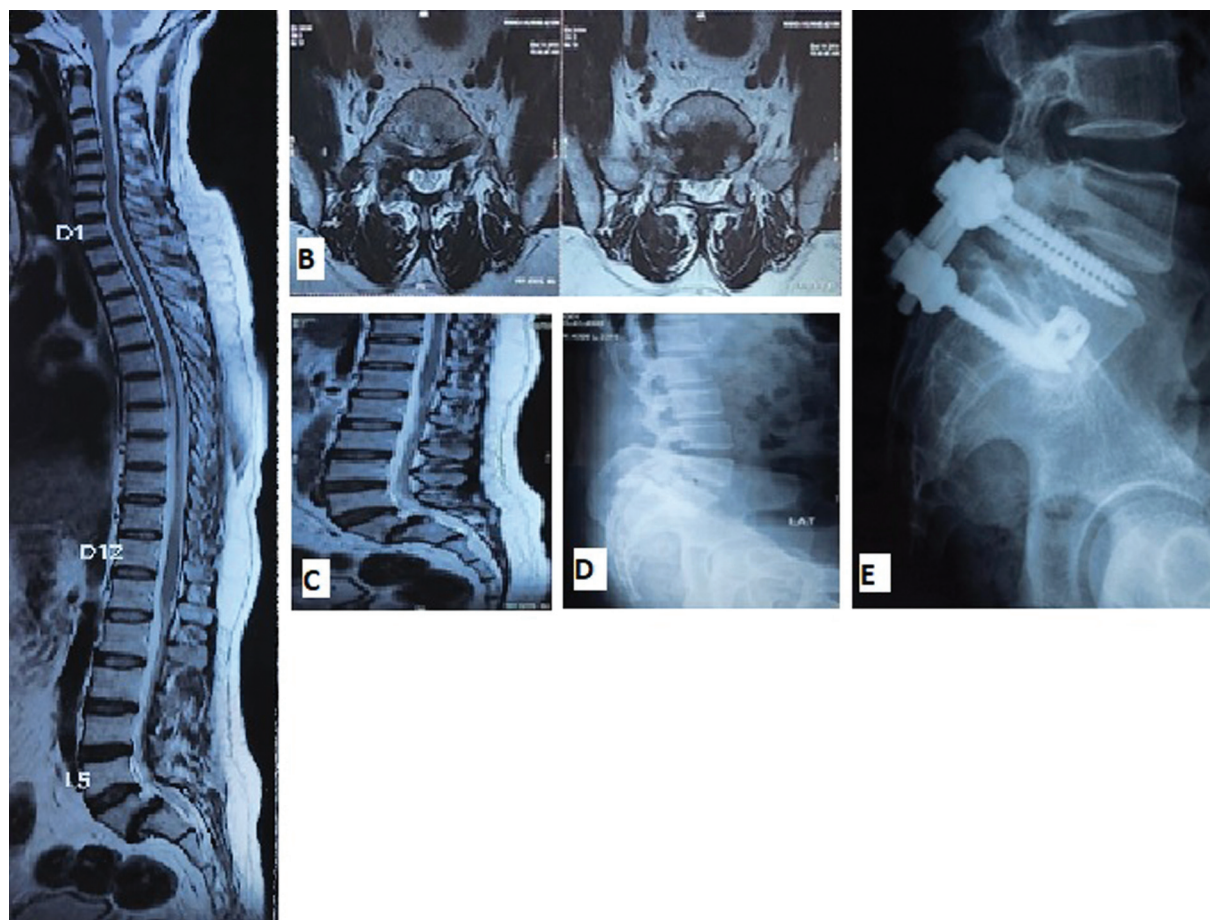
(A) MRI suggestive of Lumbarised S1-S2 listhesis, (B) Axial cuts showing disk bulge, (C) Sagittal image of L-S spine, (D) Pre-op X-ray L-S spine Lateral view showing Grade 2 listhesis, (E) Post op X-Ray Lateral view
